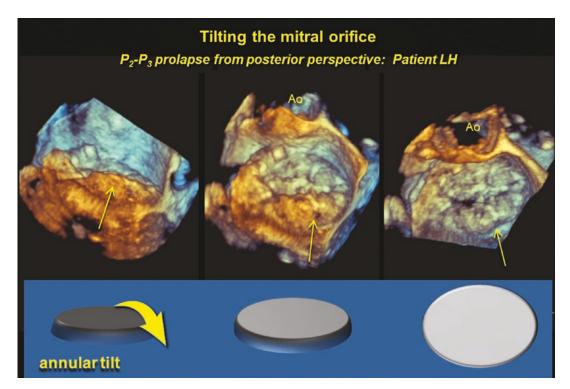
A three-dimensional echocardiogram displayed in the surgeon's view also shows flail extending into the P₃ segment. In addition, there was no coaptation
